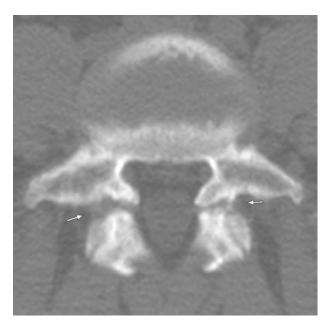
CT scan of bilateral spondylolysis (*arrows*) of vertebral body in a thin-section axial image with the gantry of the CT scanner appropriately tilted for optimal visualization.
